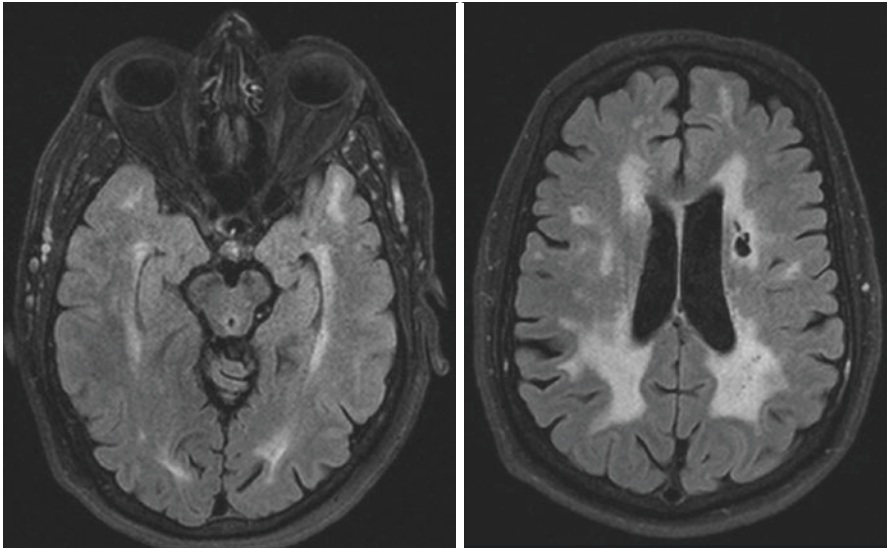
MRI of 57 year old male with CADASIL
